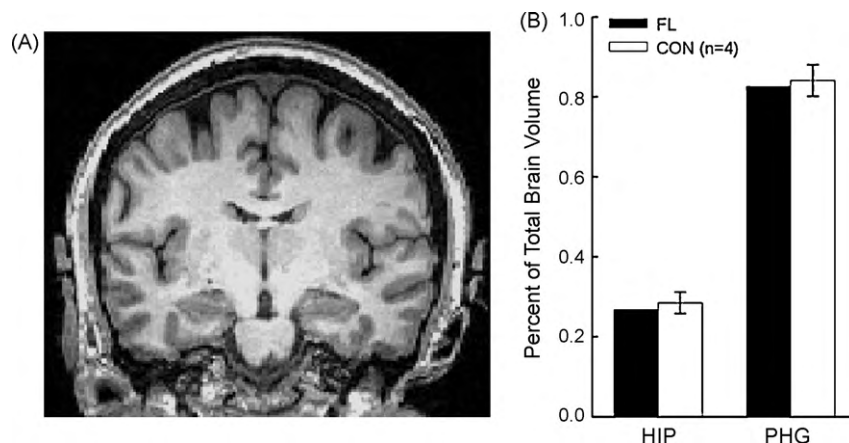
(A) A T1-weighted coronal MRI image from FL. The left side of the brain is on the left side of the image. (B) The volume of bilateral hippocampus (HIP) and parahippocampal gyrus (PHG) were similar for FL and controls ($n=4$). The volumes are expressed as a percentage of the whole-brain volume for each participant.
